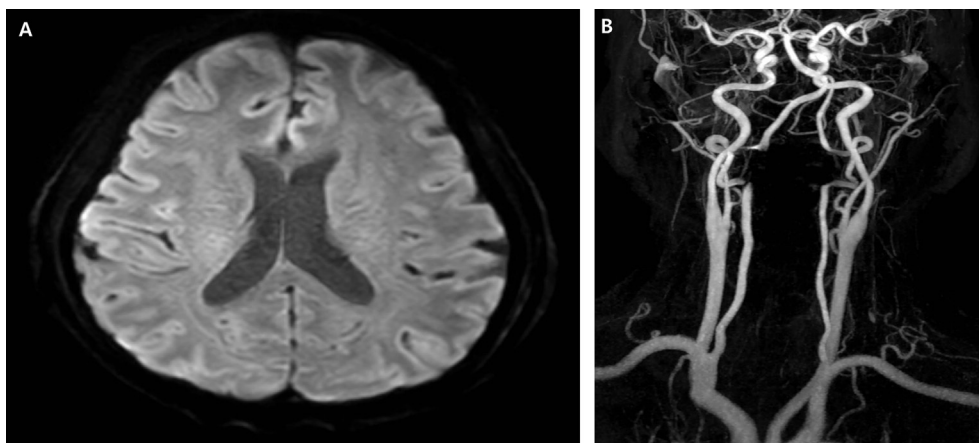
Brain and vertebral artery were intact. (A) Diffusion weighted MR image, and (B) vertebral artery angiographic MR image. The left C1 lateral mass screw is observed within the C1 lateral mass where less than 50% of the diameter of the screw violates the surrounding cortex (C). Both C2 pedicle screws are located completely within the bony cortex (D).
